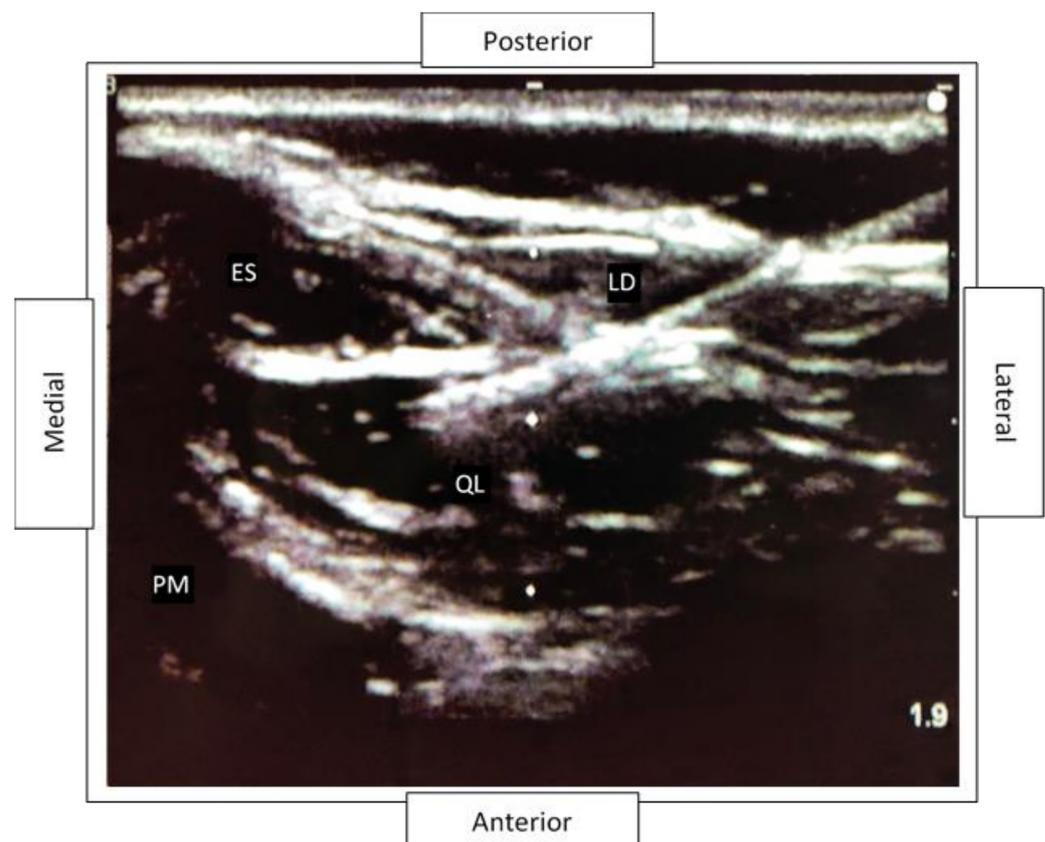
Ultrasound of block administration plan; QL—quadratus lumborum. LD—latissimus dorsi. ES—erector spinae. PM—psoas major.
